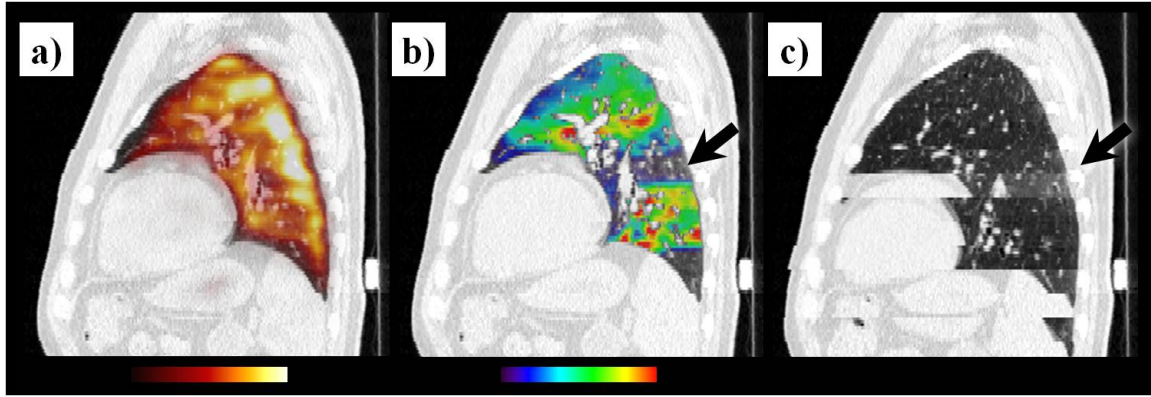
Multimodal image alignment. a) The CT component of the SPECT-CT perfusion study is shown in yellow overlain the corresponding T50 phase image from 4D CT, following affine registration as described above. b) The SPECT perfusion is similarly shown. Spatial alignment error is clearly visible along the right lung boundary. Note that no such misalignment is present in (a). c) SPECT perfusion is shown overlain the T50 component image, following manual adjustment of the volumetric image approximately 5 mm laterally to account for shifts in patient position between SPECT and CT acquisitions.
